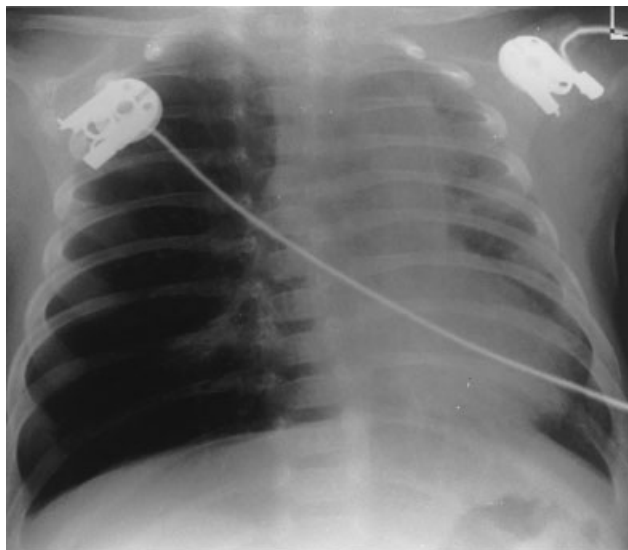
Chest X-ray of case 1 shows overinflation of right lung with marked mediastinal shift at left. Small area of atelectasis is in medial segment of right middle lobe, and left lower lobe is partially collapsed.
